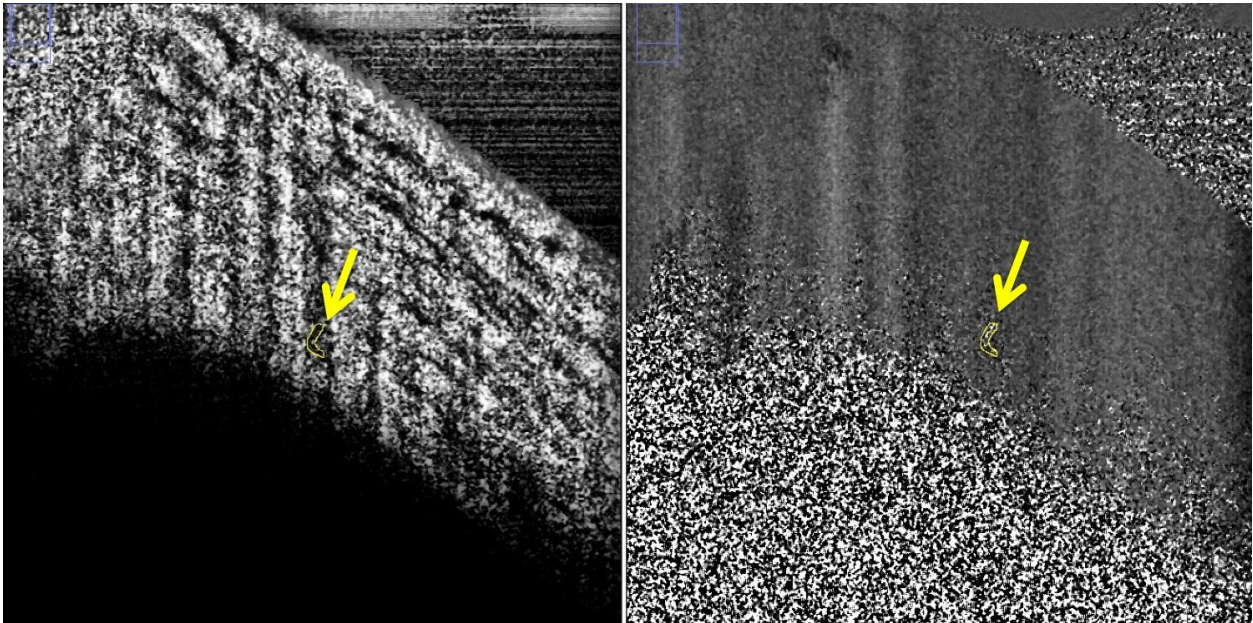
Some small regions presented with consistent Doppler signal, but in very small areas.
